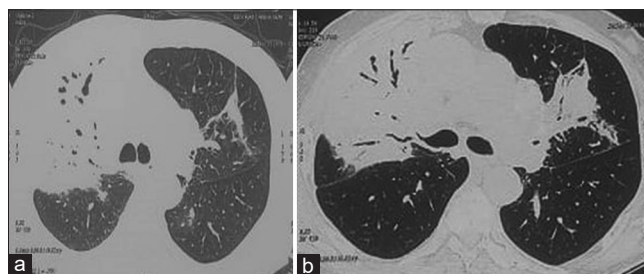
(a) Lung window images of computed tomography chest (2018). (b) Lung window images of computed tomography chest (2019)
